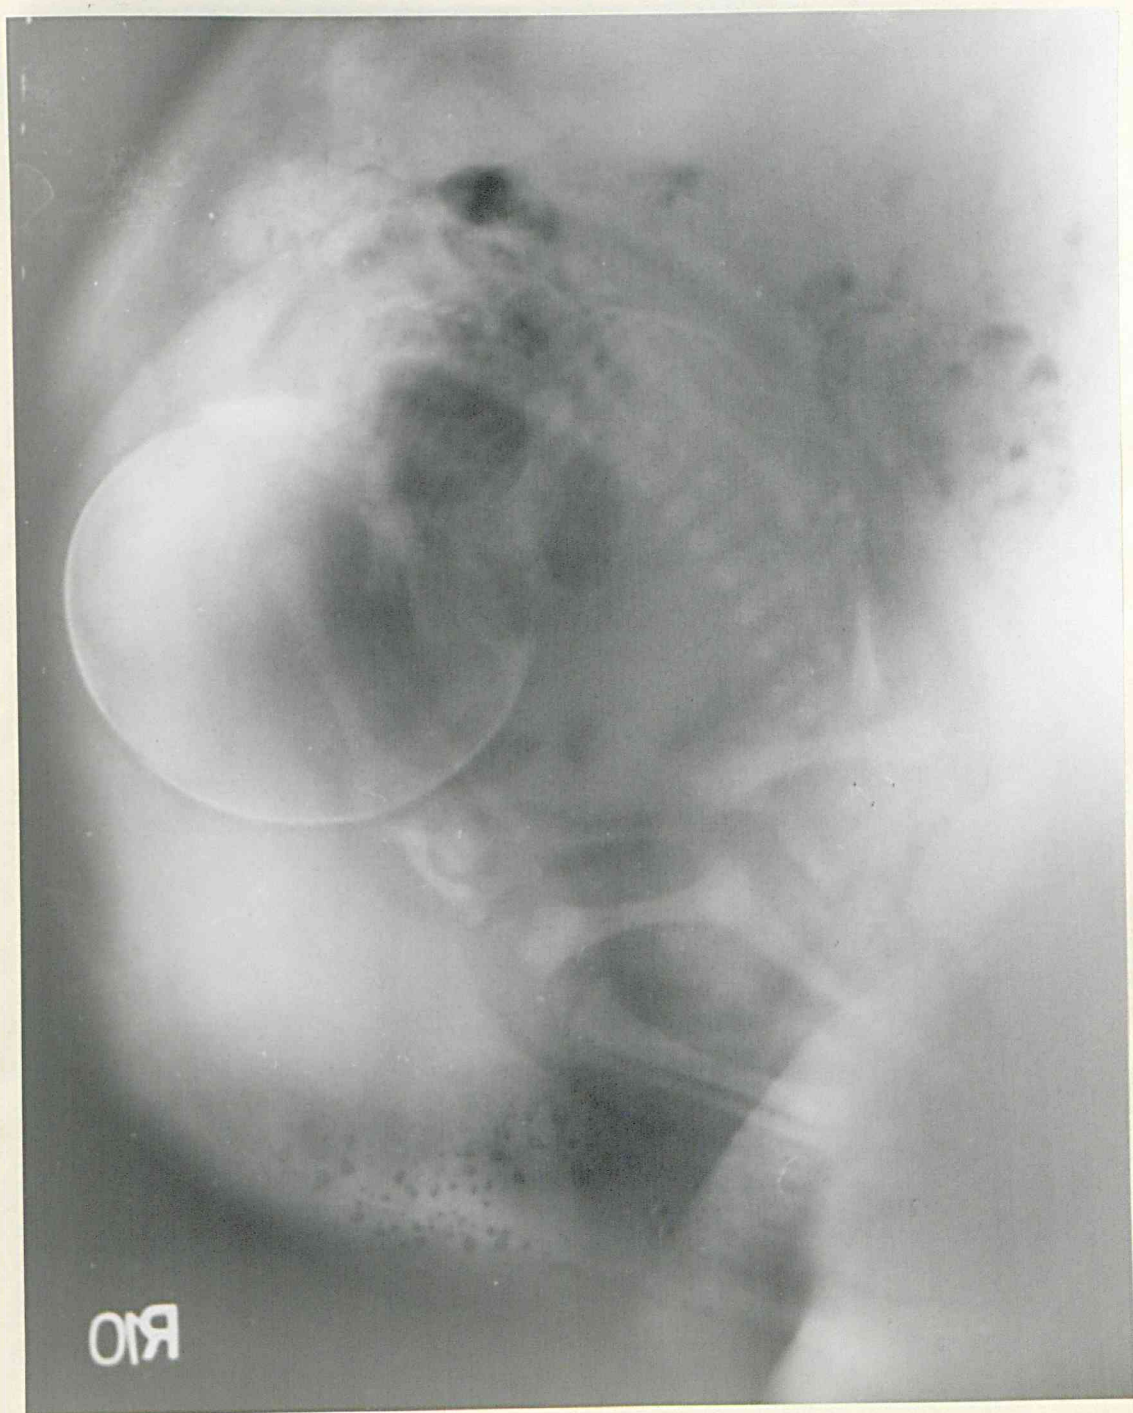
Lateral radiograph of the abdomen in a case of breech presentation. The unilateral thickening corresponding to the placenta is on the anterior wall of the upper uterine segment. (Case No. 211).
